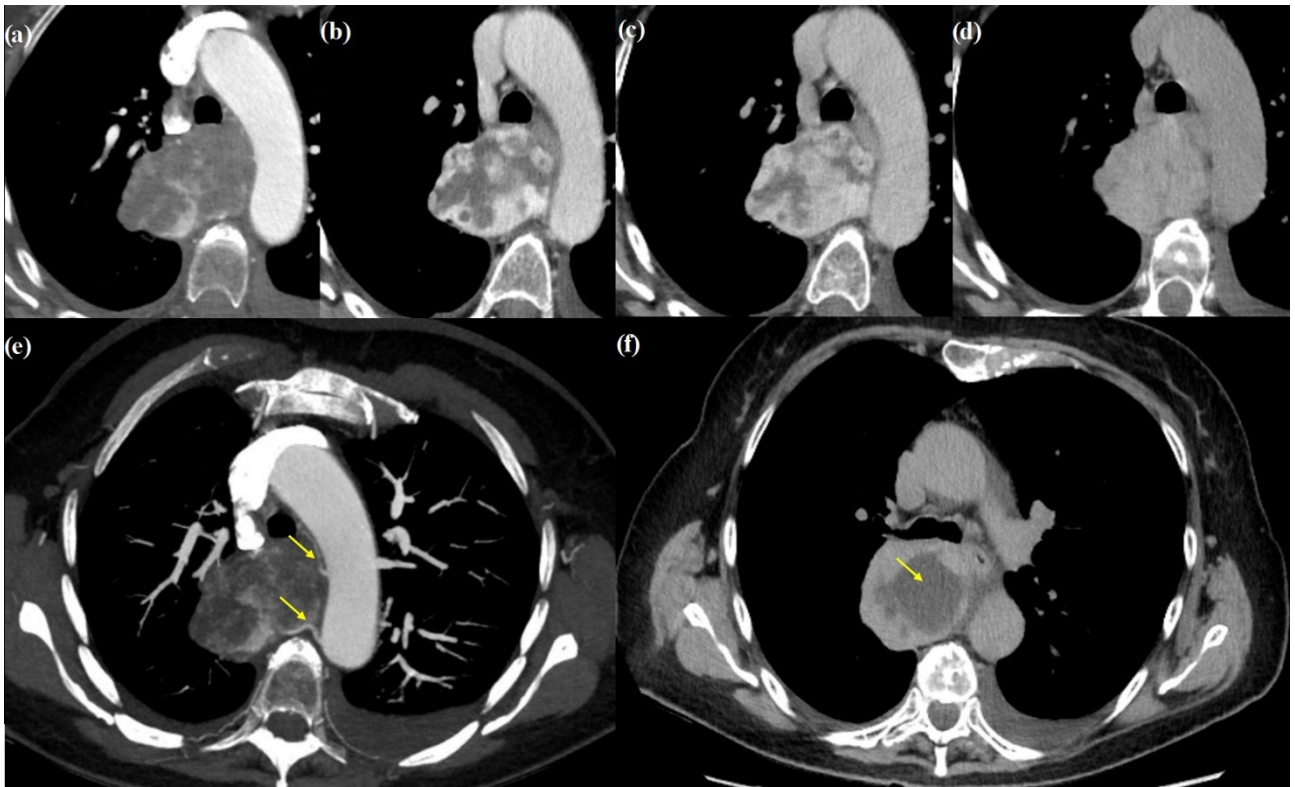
Enhanced CT scan study of the mediastinal mass.
